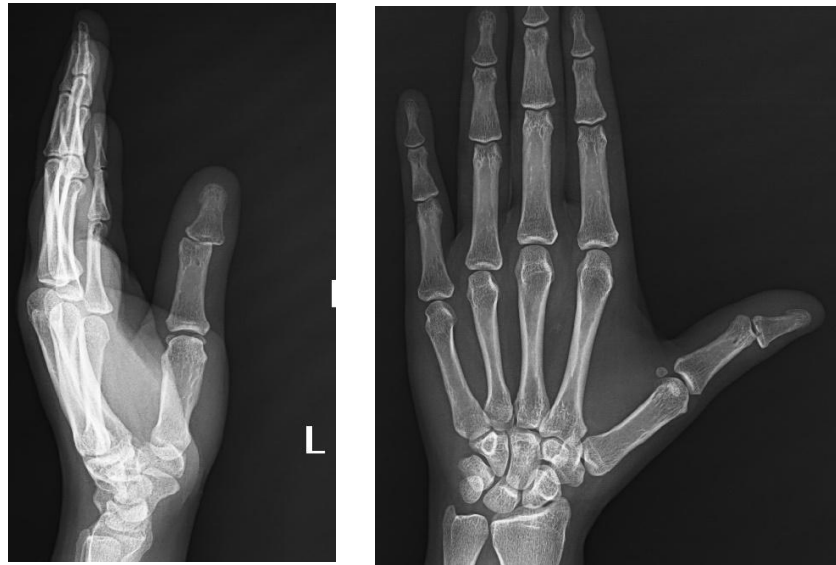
Pre-operative x-ray showing the thumb IP joint dislocation
